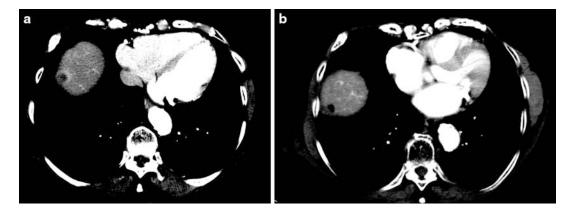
Endometrial cancer liver metastasis before (a) and 9 months after SBRT (b). Note the loss of rim contrast enhancement in post contrast arterial phase CT scans. A cyst-like remnant can be observed after SBRT
